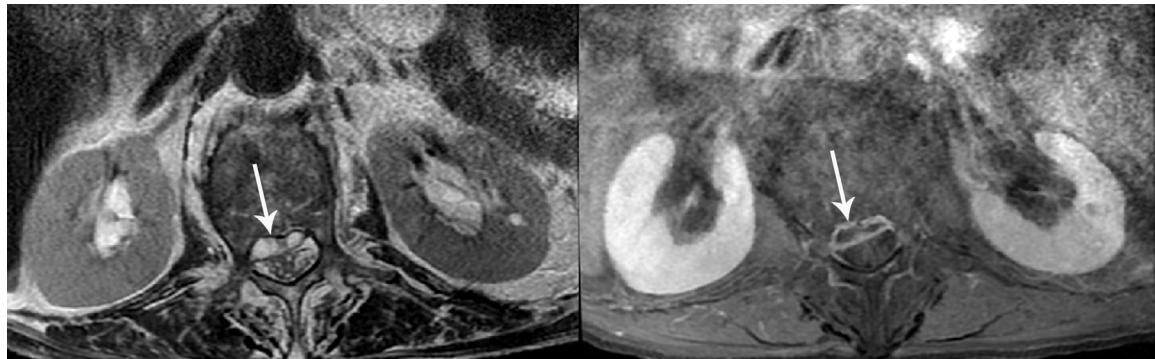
Lumbar spinal anterior epidural empyema showing high signal on axial T2-weighted MRI (Left) and intense peripheral enhancement on postcontrast T1-weighted MRI (arrows) (Right).
